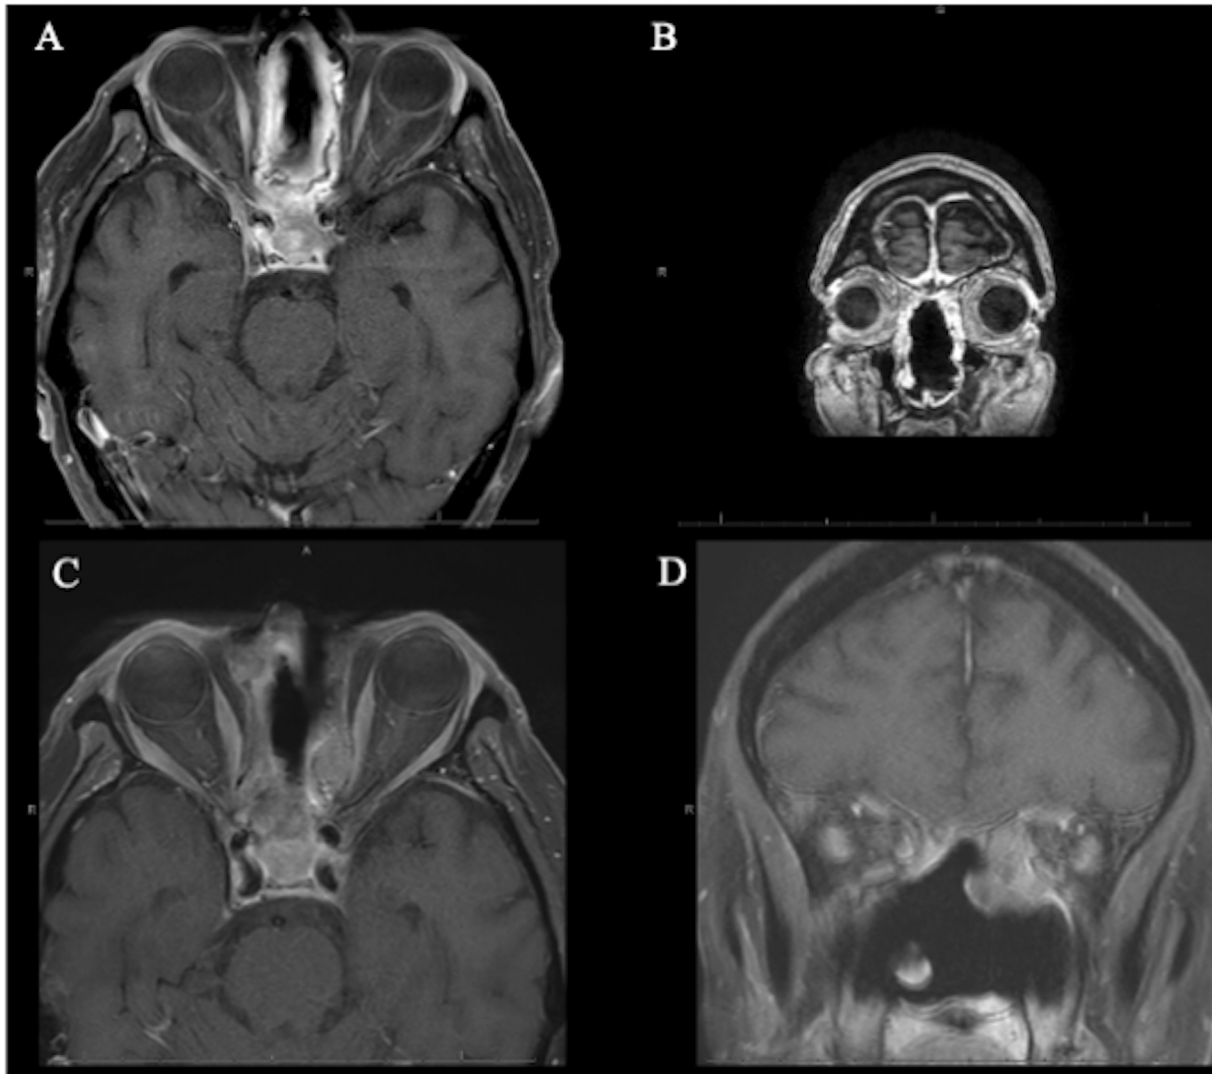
Postoperative magnetic resonance imaging (MRI) (A, B) demonstrating changes consistent with extensive sinonasal surgery with skull base reconstruction. Post-incomplete chemoradiation therapy MRI (C, D) demonstrating recurrence of sinonasal tumor.
